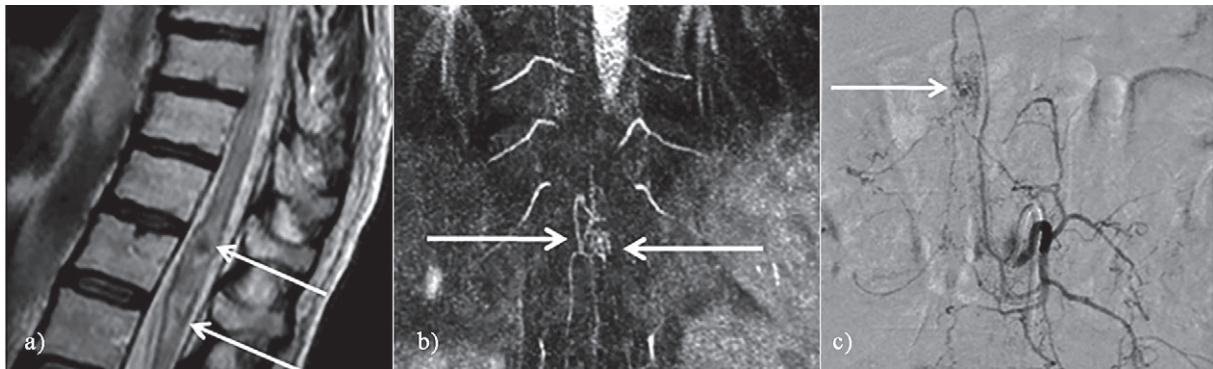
Preoperative; sagittal T2-weighted (a) image revealed intramedullary hemorrhage in the spinal cord extending from the T11-12 level to the conus (arrows). The high resolution contrast enhanced MRA (b) demonstrated tortuous vascular structures (arrows). Spinal DSA (c) from the left L1 intercostal artery demonstrated an AVM (arrow) which was supplying by ASA.
